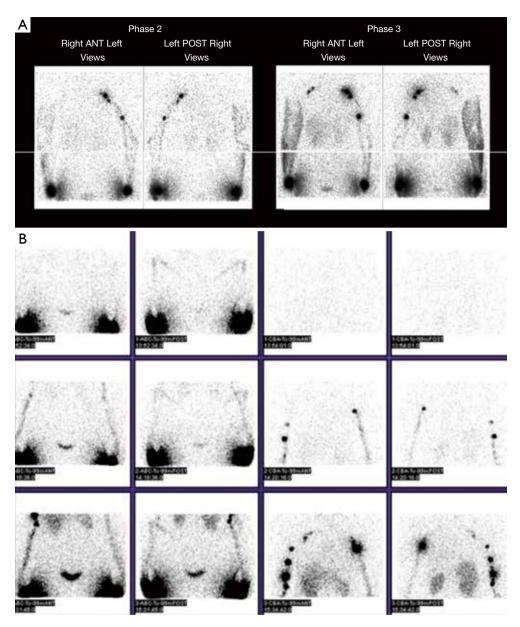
Typical images of lymphoscintigraphy. (A) A patient with right side severe upper limb lymphedema. On the second phase, only a beginning progression can be seen on the right side with beginning diffuse tracer diffusion, whereas on the left side the tracer has reached the axilla through linear lymphatic channels. On phase three a massive dermal back-flow can be seen over the whole right upper limb, with little axillary nodes. (Images courtesy of Pierre Bourgeois. Dept of dermatology, Erasme University Hospital, Brussels, Belgium). (B) Moderate right upper limb lymphedema. Bilateral lymphatic insufficiency at rest (no tracer progression). Recruitment of deep lymph nodes seen on the right side. (Images courtesy of Pierre Bourgeois. Dept of Dermatology, Erasme University Hospital, Brussels, Belgium).
